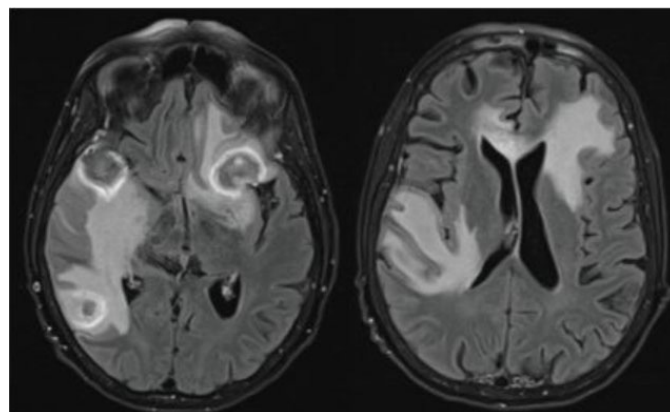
Stealth MRI showing interval enlargement of all four dominant intra-axial masses.
